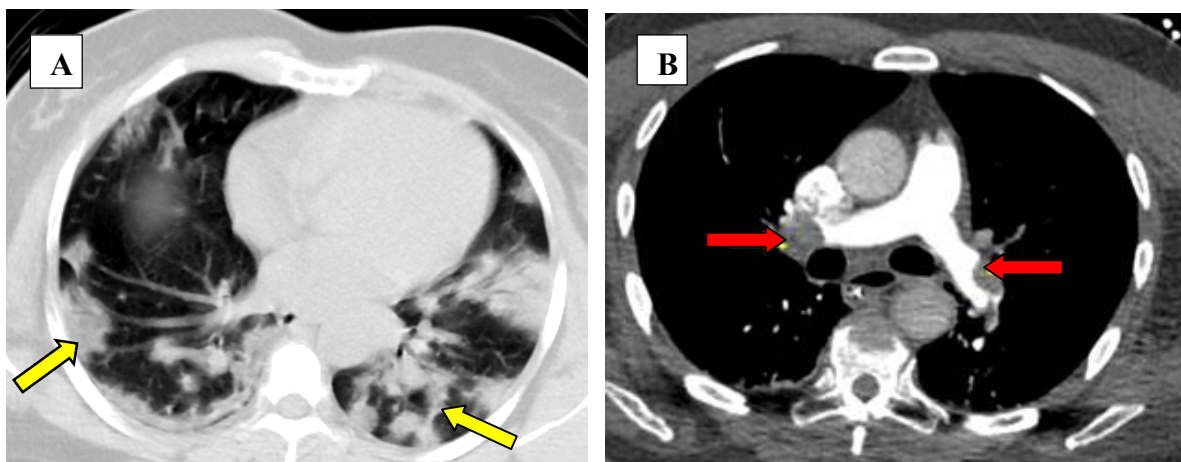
(A) HRCT-Chest axial section showing multiple patchy peripheral ground glass opacities (yellow arrows) in bilateral lung fields (B) CTPA of the chest in the axial projection at the level of the main pulmonary artery bifurcation shows large filling defects of the right and left pulmonary arteries (red arrows)
